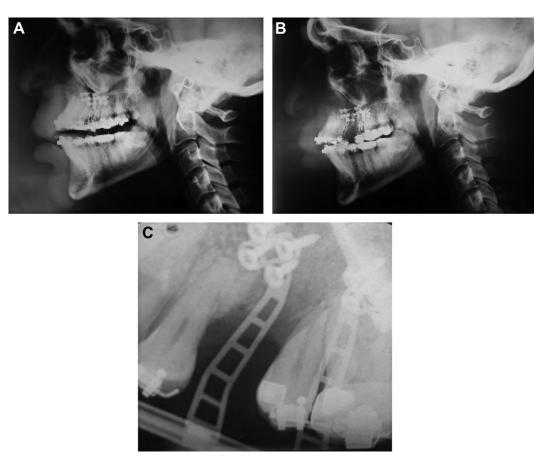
(*A*) Lateral cephalogram taken immediately after the surgery. (*B*) Lateral cephalogram taken at the end of the distraction phase, at the start of the consolidation phase. Note the presence of the bone gaps between the roots of the bicuspid teeth. (*C*) Periapical radiograph showing the bone fill in the distracted bone between the tooth roots during the consolidation phase. Dental implants are used to restore these spaces.
